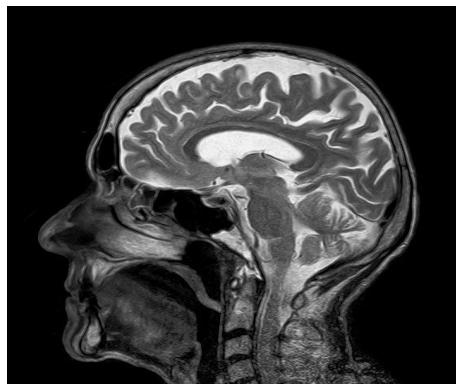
Example of MRI Scan
